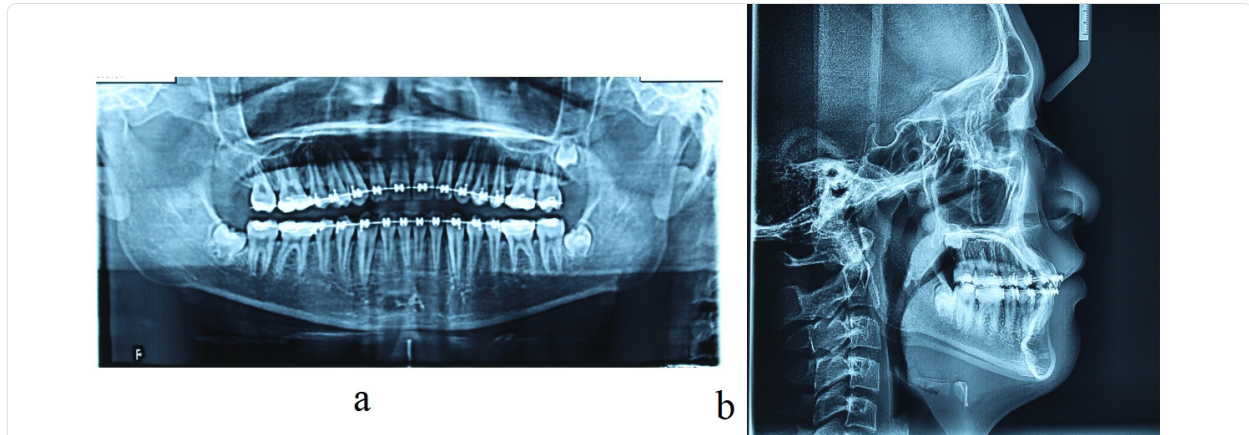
a) Panoramic radiograph prior to debond b) Lateral cephalogram prior to debond
